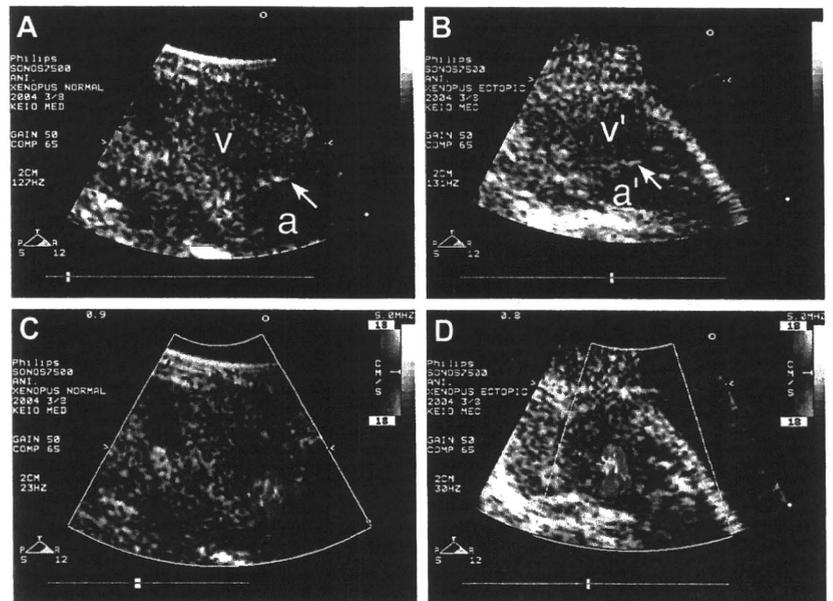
Echocardiography of the dual-heart frogs. (A) Two-dimensional echocardiogram of normal heart, showing atrium (a) and ventricle (v). Valve-like tissue (arrow) is visible between these two chambers. (B) Two-dimensional echocardiogram of the ectopic heart. As with the normal heart, two chambers are apparent and valve-like tissue (arrow) is visible between the atrium-like (a') and ventricle-like (v') structures. Also see Supplemental movie 3. (C) Color Doppler echocardiography of the normal heart. (D) Color Doppler echocardiography of the ectopic heart. Also see Supplemental movie 3. Blood flow between the two chambers is indicated by color (red, blood flow towards probe; blue, flow in the opposite direction).
